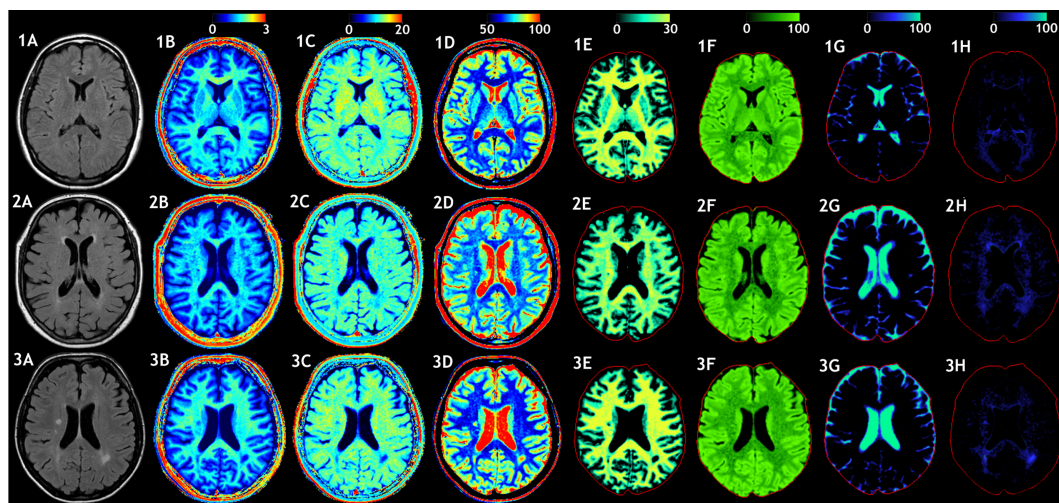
Examples of the model calculation on an axial slice of the brain. (row 1) Healthy subject, female 45 years old, (row 2) elderly control subject, female 72 years old, and (row 3) patient, female, 45 years old, diagnosed with secondary progressive MS. (A) A conventional FLAIR image of the same slice is added as a visual reference. (B) The measured R_1 relaxation rate is shown on a scale of 0–3 s⁻¹, (C) the R_2 relaxation rate is shown on a scale of 0–20 s⁻¹, and (D) the proton density PD is shown on a scale of 50–100%, where 100% corresponds to pure water at 37°C. (E) Using the R_1 , R_2 , and PD values in combination with the look-up grid of Figure 4 the myelin partial volume V_{MY} was calculated, as shown on a scale of 0–30%. (F) the cellular partial volume V_{CL} , (G) free water partial volume V_{FW} , and (H) excess parenchymal water partial volume V_{EPW} were all calculated all on a scale 0–100%. The red intracranial cavity outline is displayed in all tissue images for visual guidance.
